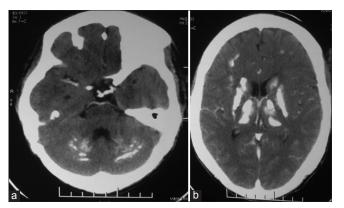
1.1,1.2 CT brain of patient mentioned in case 1
